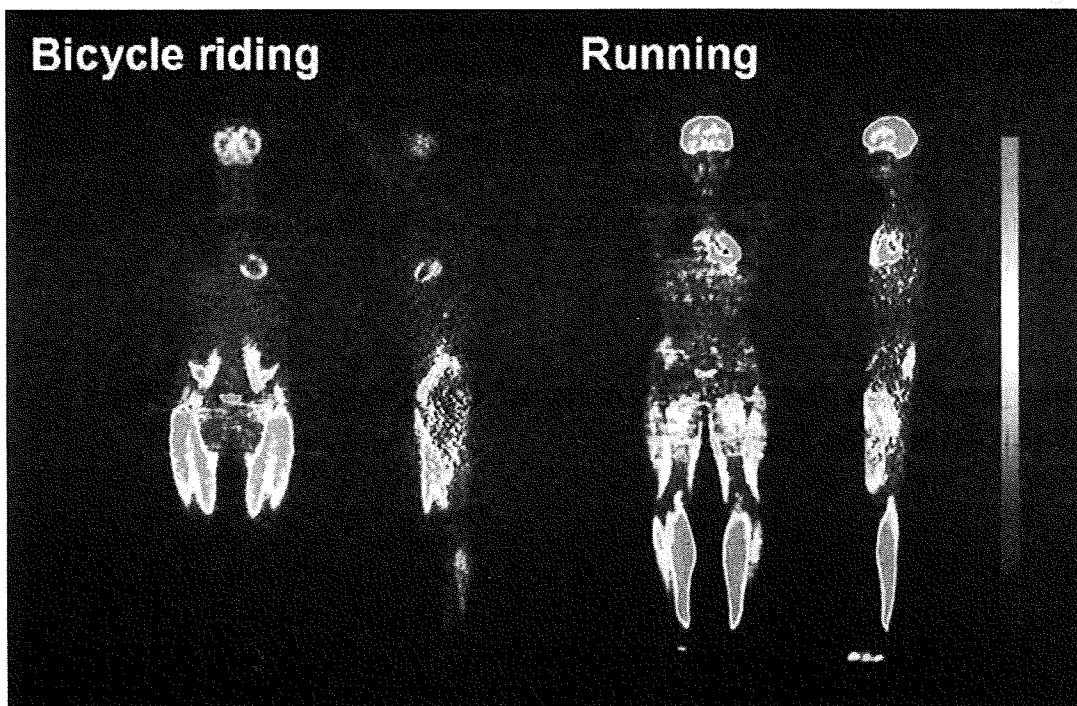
An example of [^{18}F]FDG PET use in exercise physiology. A clear difference can be seen between bicycle riding (*left*) and running (*right*).
